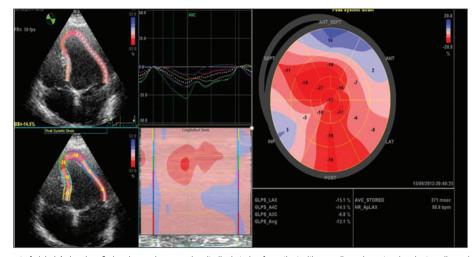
Assessment of global 4 chamber, 2 chamber and avarage longitudinal strain of a patient with non-dipper hypertension by two-dimensional speckle tracking echocardiography.
